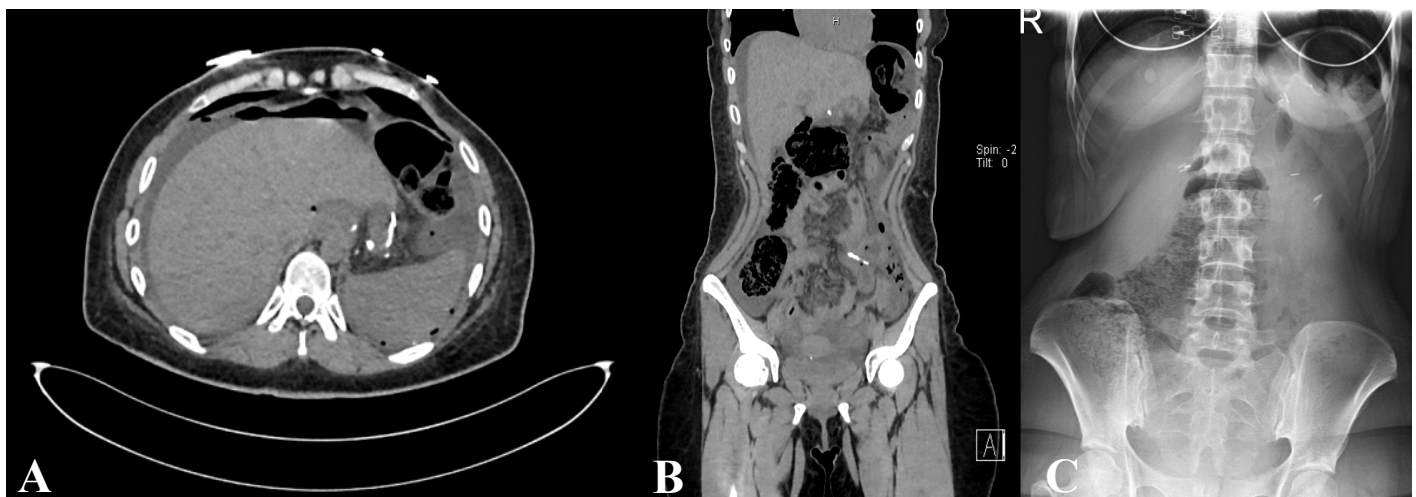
Subdiaphragmatic free gas in the anterior hepatic space with erect abdominal x-ray. 1B. Perihepatic, perisplenic free fluid and gas with contrast abdominal CT. 1C. Stapler line at jejunojejunal anastomosis site and perforation side with contrast abdominal CT
